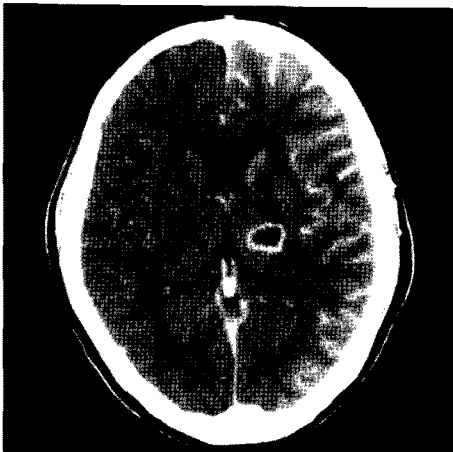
Postangiographic brain CT scan shows gyriform enhancement of the left cerebral cortex and thalamus.
